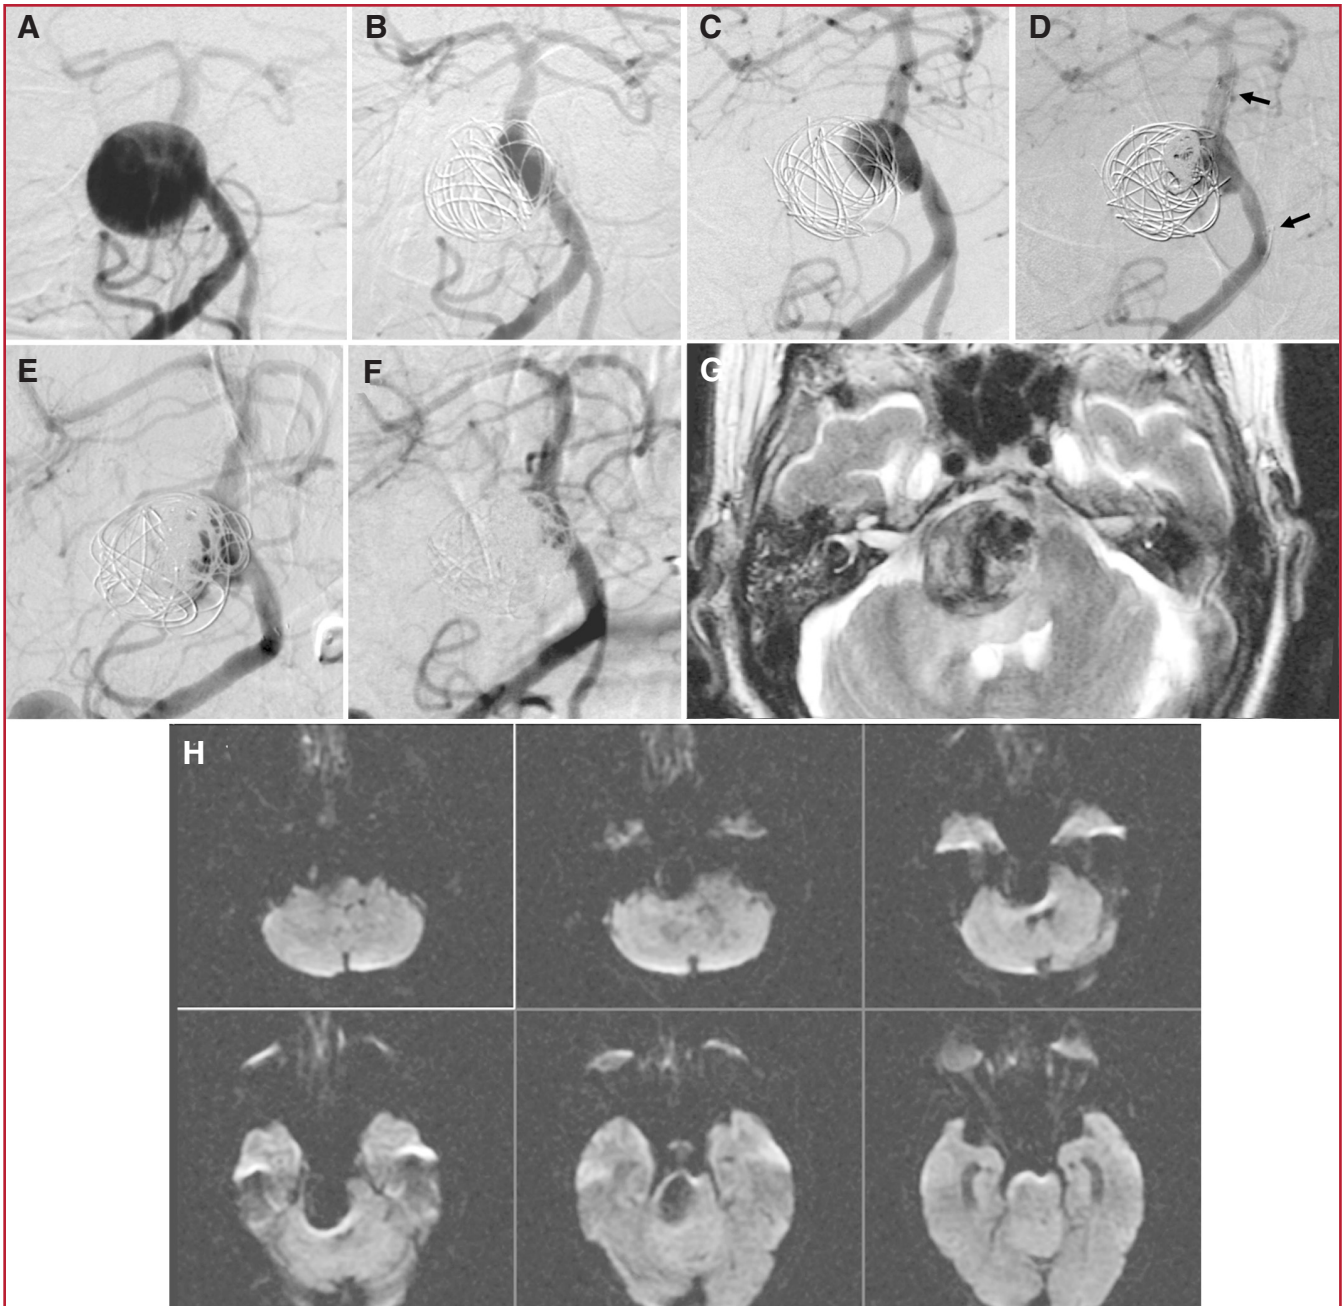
Patient 10. A, right vertebral angiogram showing a giant midbasilar aneurysm with a poorly defined neck. B, angiogram 1 month after stent reconstruction of the midbasilar artery supplemented by partial aneurysm coiling. Much of the aneurysm appears thrombosed. C, aneurysm recanalization 4 months later. D, this was treated with placement of a second stent (arrows) and further coil embolization. The aneurysm recanalized again (E), and a third coil embolization was performed (F) 1 month later. T2- (G) and diffusion-weighted (H) magnetic resonance imaging (MRI) sequences demonstrate marked brainstem compression without evidence of infarction.
